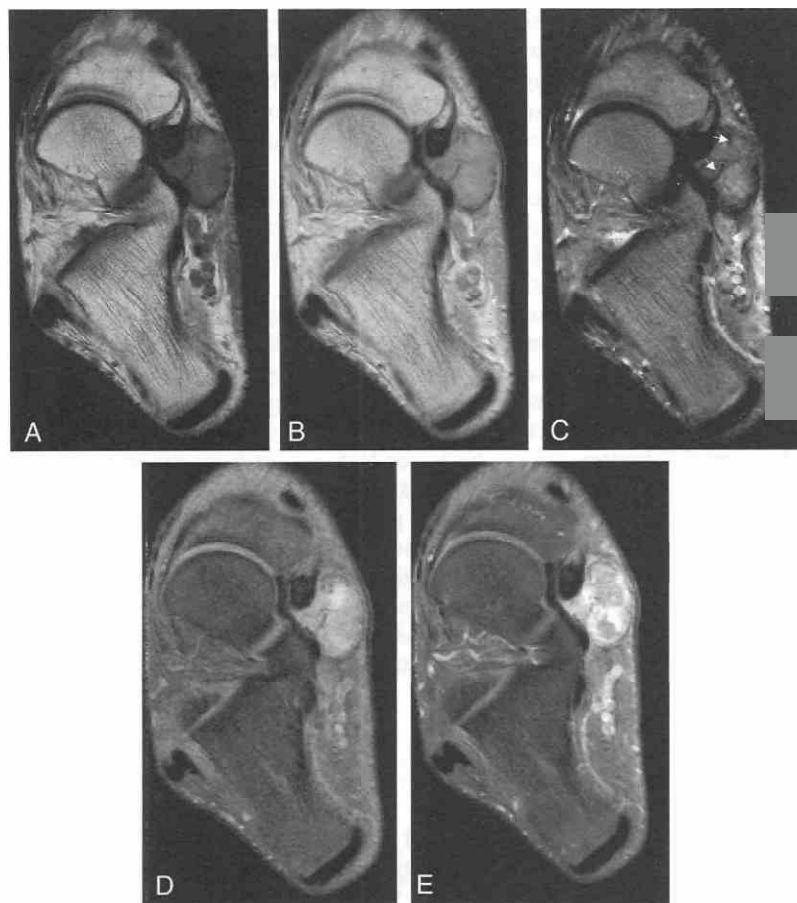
Giant cell tumor of the tendon sheath in a 19-year-old man. *A*, Axial T1-weighted image. *B*, Axial proton-density-weighted image. *C*, Axial T2-weighted image. The soft tissue mass adjacent to the posterior tibial tendon is relatively dark on the T1-weighted and T2-weighted images owing to the presence of hemosiderin. The mass is growing through the torn tendon sheath (arrows). *D*, Axial precontrast fat-suppressed T1-weighted image. Some signal within the mass is brighter than the surrounding suppressed fat, suggesting the presence of proteinaceous fluid or methemoglobin. *E*, Axial postcontrast fat-suppressed, T1-weighted image demonstrates heterogeneous enhancement, indicative of the vascularity of such synovial proliferation.
